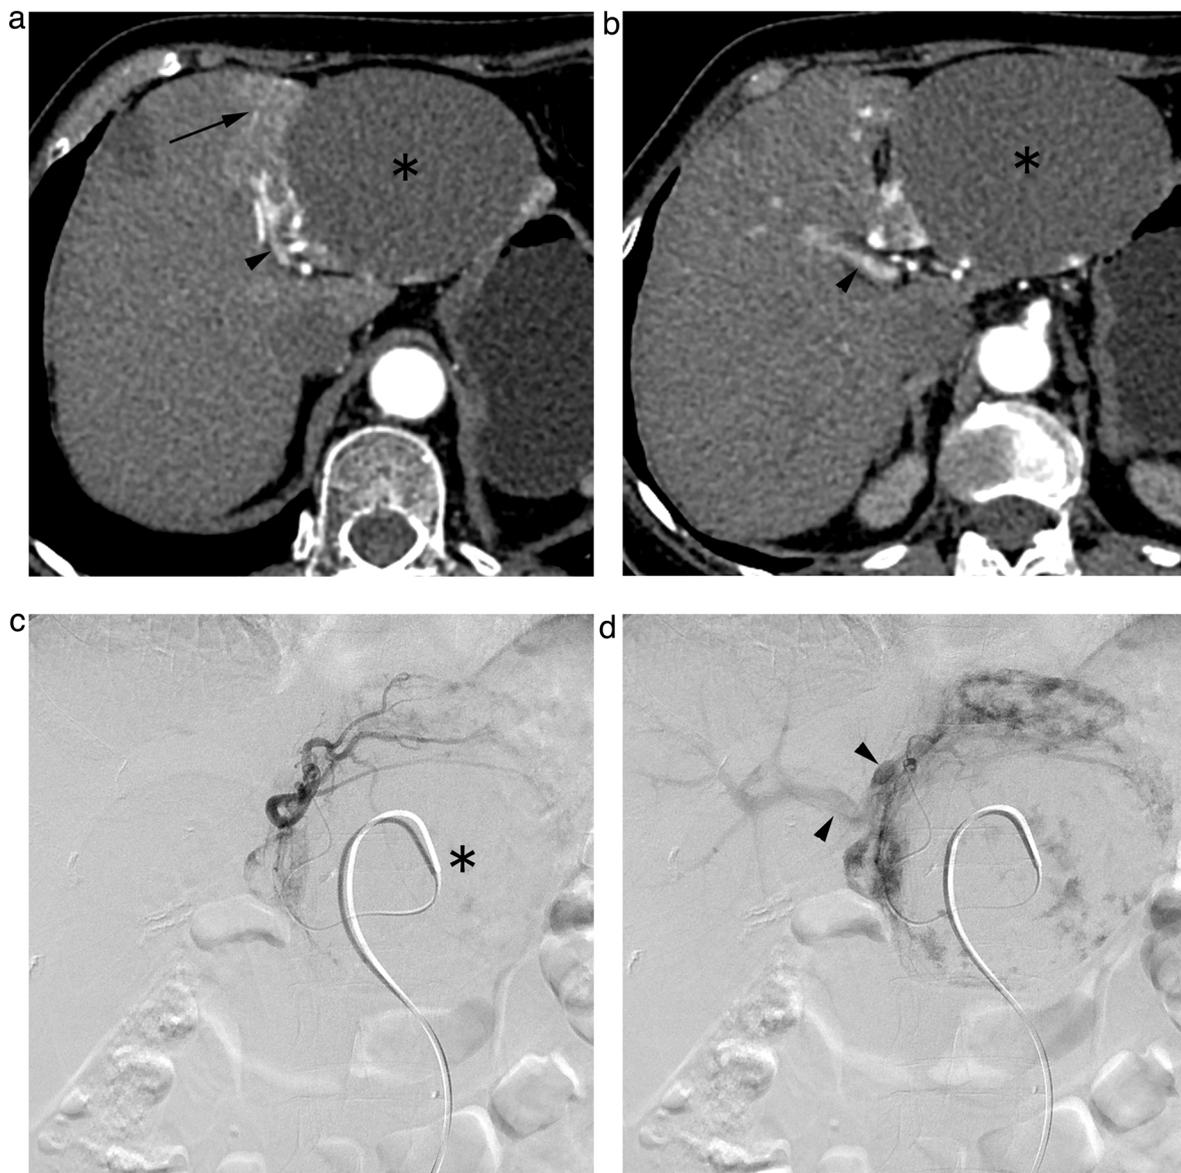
Central APS associated with a large HH. (a,b) Contrast-enhanced axial CT images obtained during hepatic arterial phase show a large HH (asterisk) in segment II and III. Note that the early peritumoral parenchymal enhancement (arrow, a) and opacification of the left (arrowhead, a) and right portal trunk (arrowhead, b), which is comparable to the central APS. (c) Selective common hepatic arteriogram obtained during the early arterial phase confirms the hypervascular tumor (asterisk), supplied by branches of the left hepatic artery. (d) Arteriogram obtained during the late arterial phase shows the early opacification of the left and right portal trunk (arrowhead), which is consistent with the central APS.
